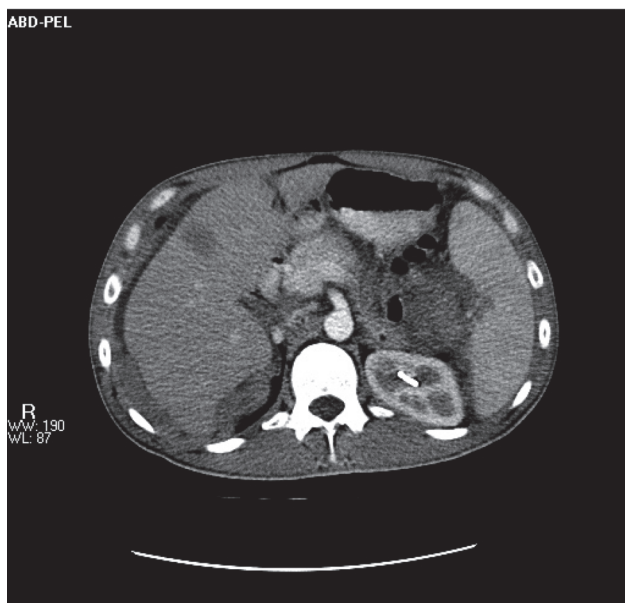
Computed tomography scan (CT scan) shows multiple heterogeneous soft tissue masses of different sizes. The smallest in the abdomen is compressing the surrounding organs, near the spleen and liver.
